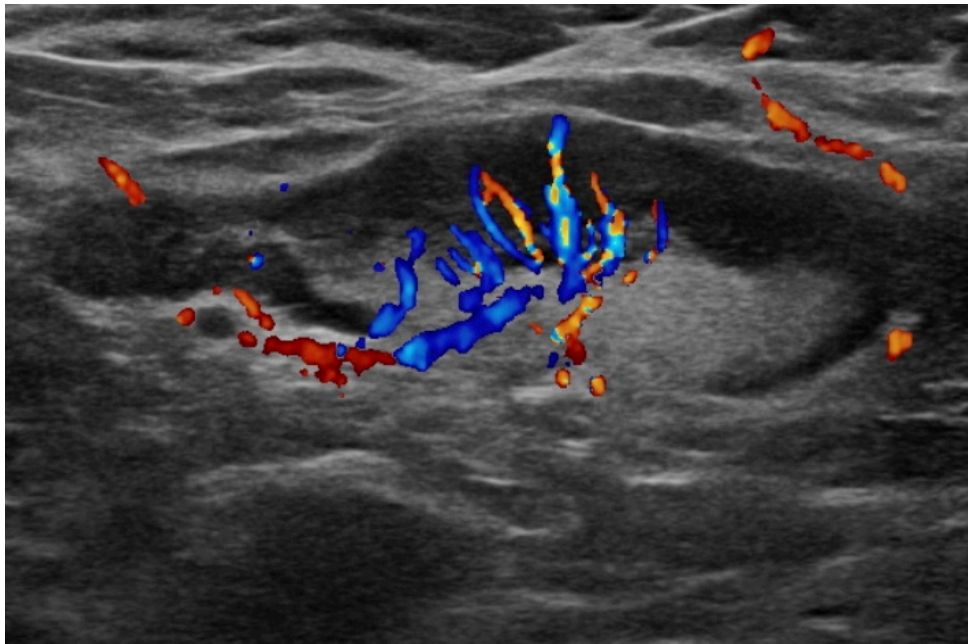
Ultrasound of an axillary lymph node with inhomogeneities in the cortex with diffuse thickening, metastasis was confirmed.
